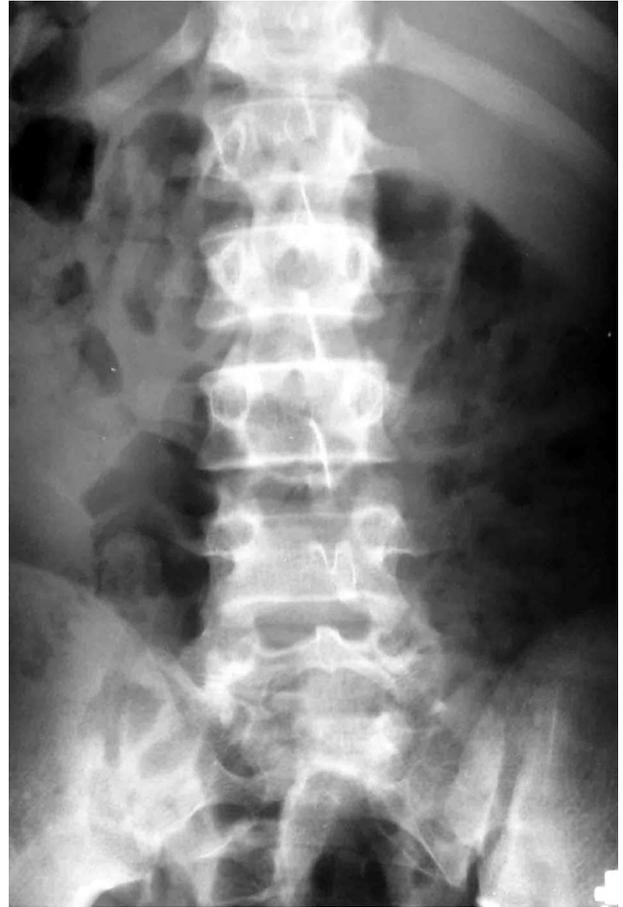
a. Anteroposterior radiography shows L2, L3 and L5 right transverse process fracture. b. Lateral radiography shows Grade 2 anterolisthesis of L5 on S1 and L4 spinous process fracture.
